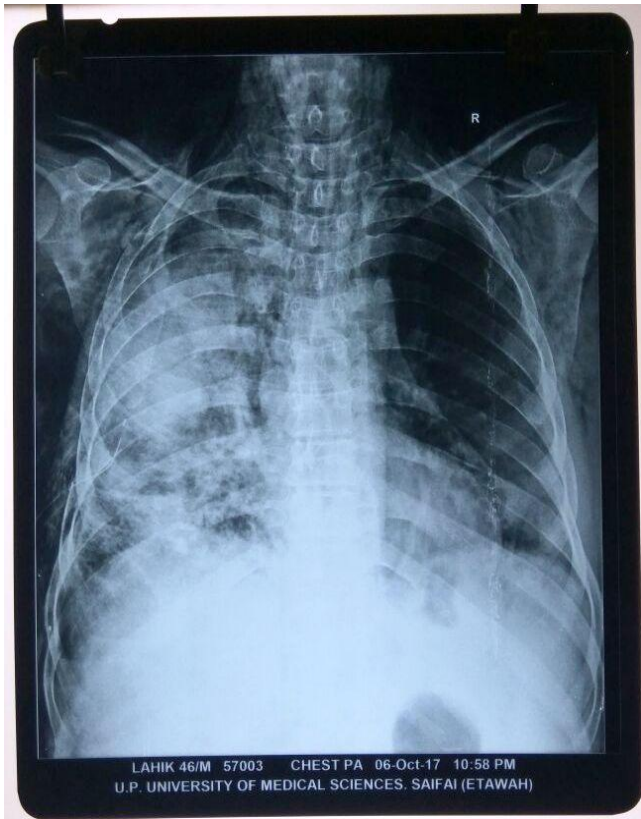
3 Chest Xray Showing Right Sided Intercostal Drainage
